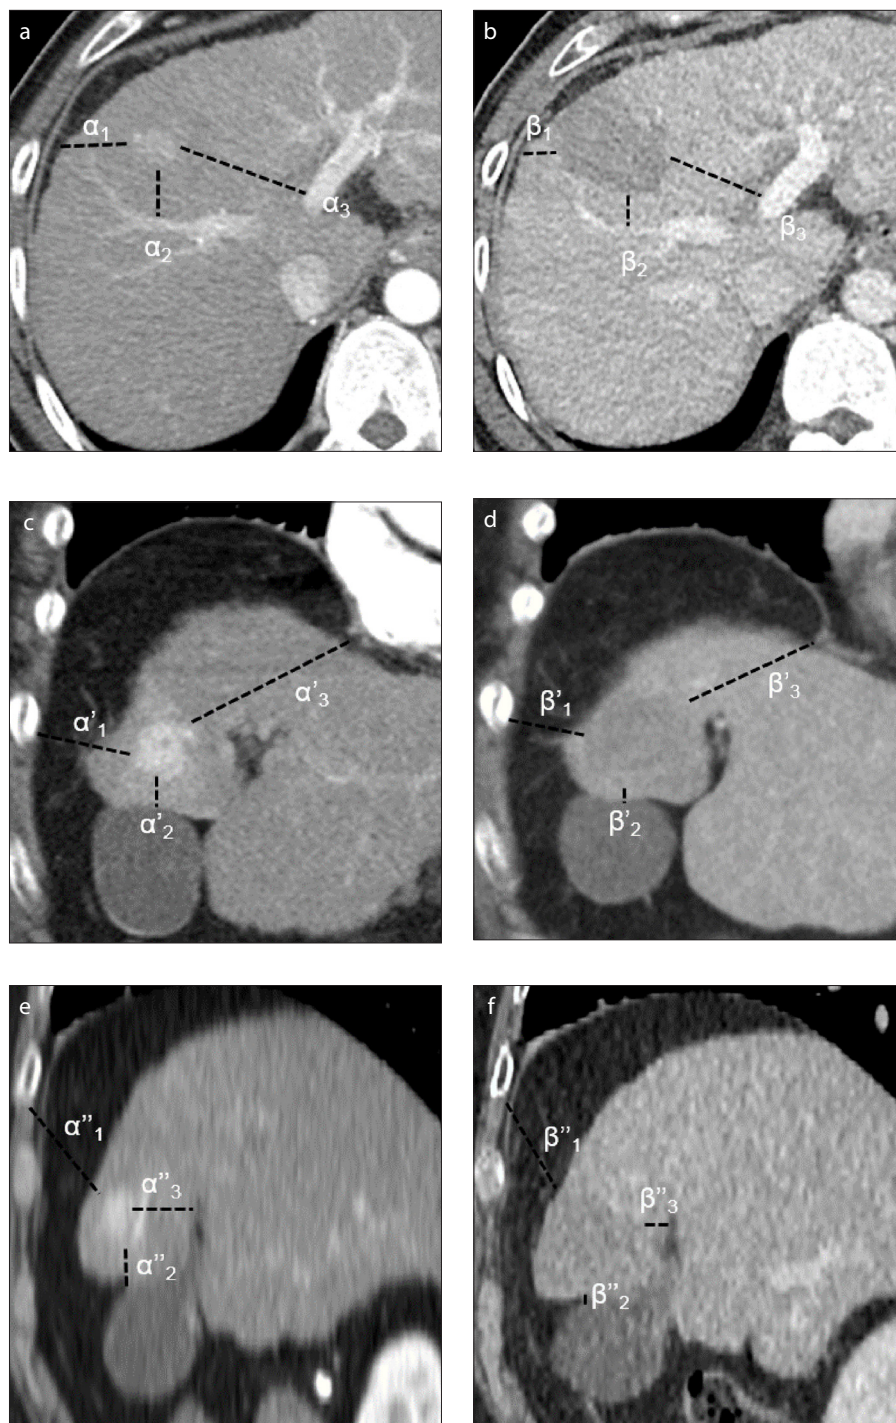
a–f. Minimal ablative margin (MAM) evaluation on each axial (a, b), coronal (c, d) and sagittal images (e, f) of computed tomography (CT). The shortest distance between pre-ablation CT (a, c, e) and post-ablation CT (b, d, f) is chosen at each plane and, among them, the shortest value of “ $\alpha_n - \beta_n$ ” is defined as MAM. In this, “ $\alpha_2 - \beta_2$ ” on axial plane is the MAM.
